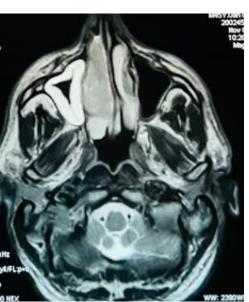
T2 MRI: neteregeneous mass of the right
